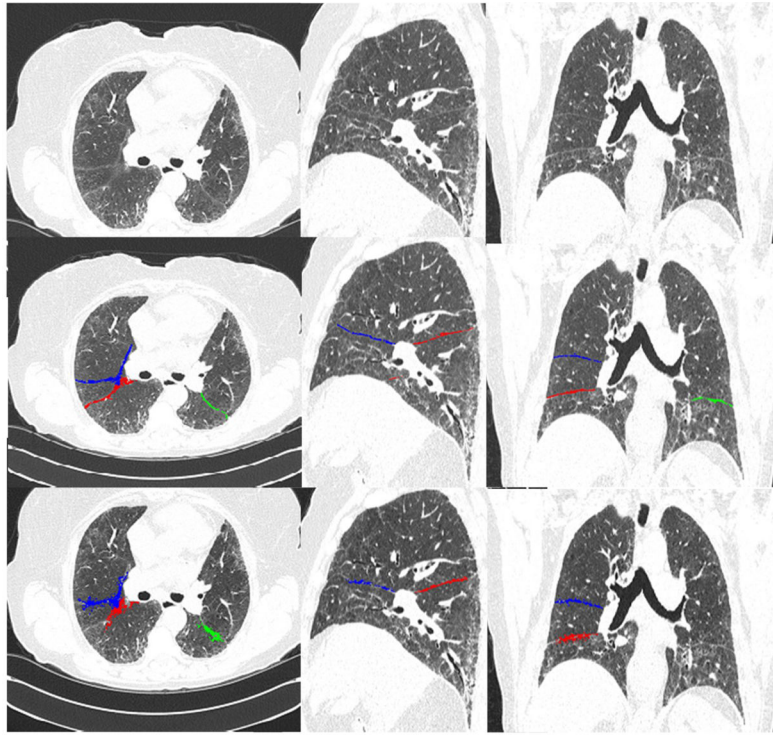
An example demonstrating the performance of the newly developed scheme, in comparison with the C-Method [7], for identifying pulmonary fissures depicted in a diseased examination with ILD (Interstitial Lung Disease). The top row shows the original CT images, the middle row shows the fissures identified by the proposed scheme, and the bottom row shows the fissures identified by the C-Method [7]. The left, middle, and right columns show the axial, the sagittal, and the coronal views, respectively.
